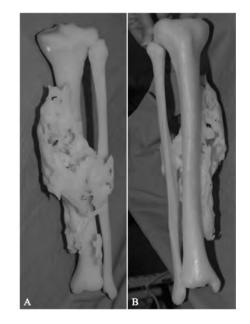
Posterior (A) and anterior (B) views of the 3D resin model constructed from the CT scan of case 2 and used intraoperatively.
